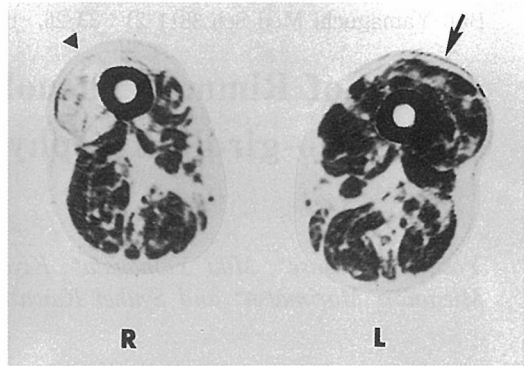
Muscle CT showing severely affected thigh muscles. Note the boule musculaire (arrow), which is not so severely replaced by fat as the right quadriceps muscle.
